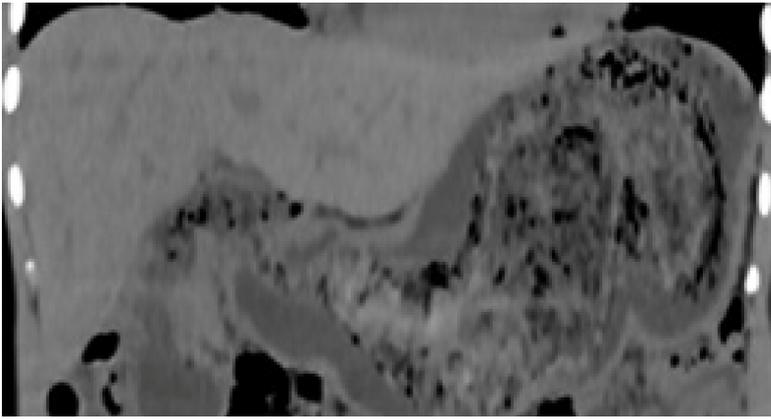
Coronary multiplanar reconstruction computed tomography image showing the extension of a hairball from the stomach into the second part of the duodenum.
